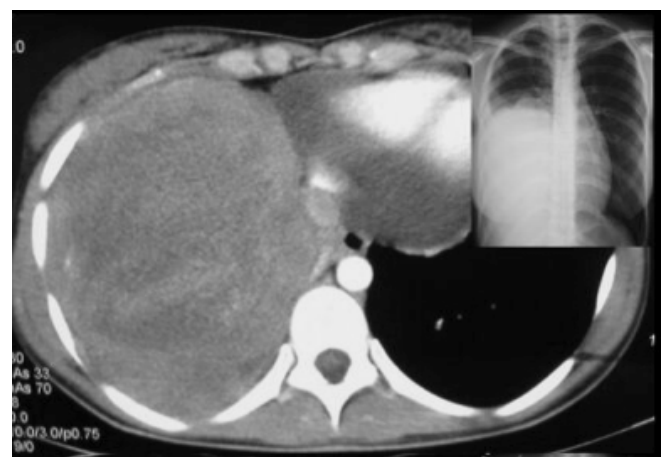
Thorax CT showing a huge Ewing sarcoma that was originated from 10th rib and 25 cm diameter, in a 21-year-old male patient.
